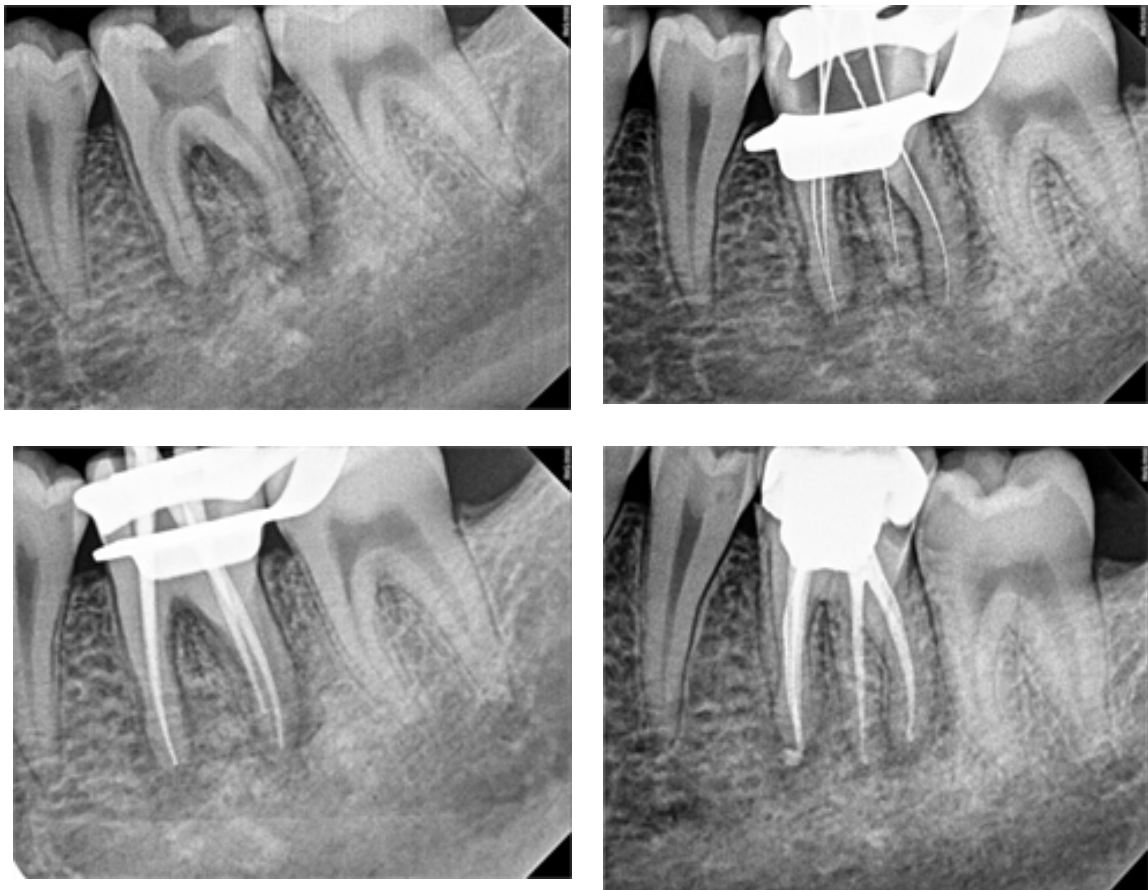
(a) Diagnostic Radiograph of 36 (b) Working length Radiograph of 36. (c) Master Cone Radiograph. (d) Post Obturation Radiograph.
